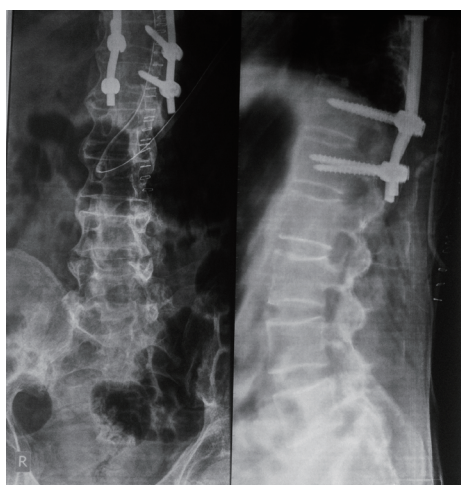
X-ray of the dorsolumbar spine showing bambooing of the spine and posterior spinal fixation for the fractured vertebrae
